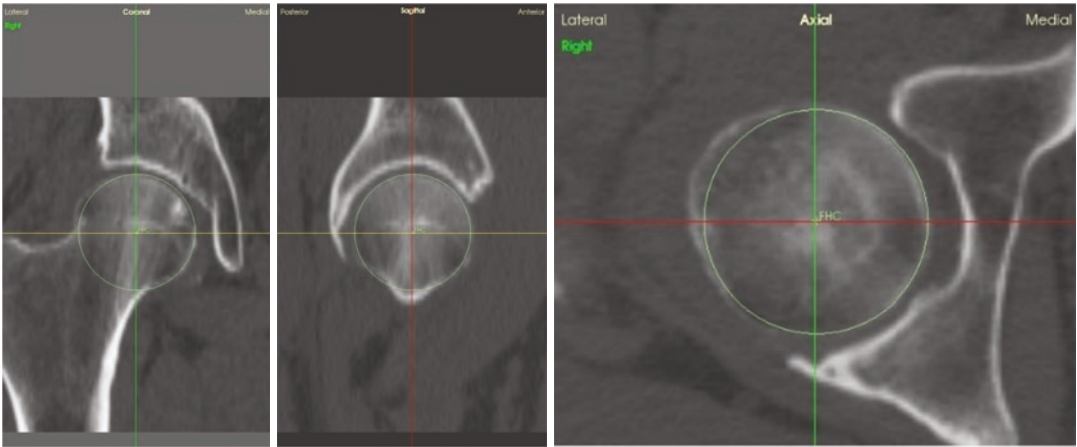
CT slices of a patient's hip and the center of the femoral head selected
